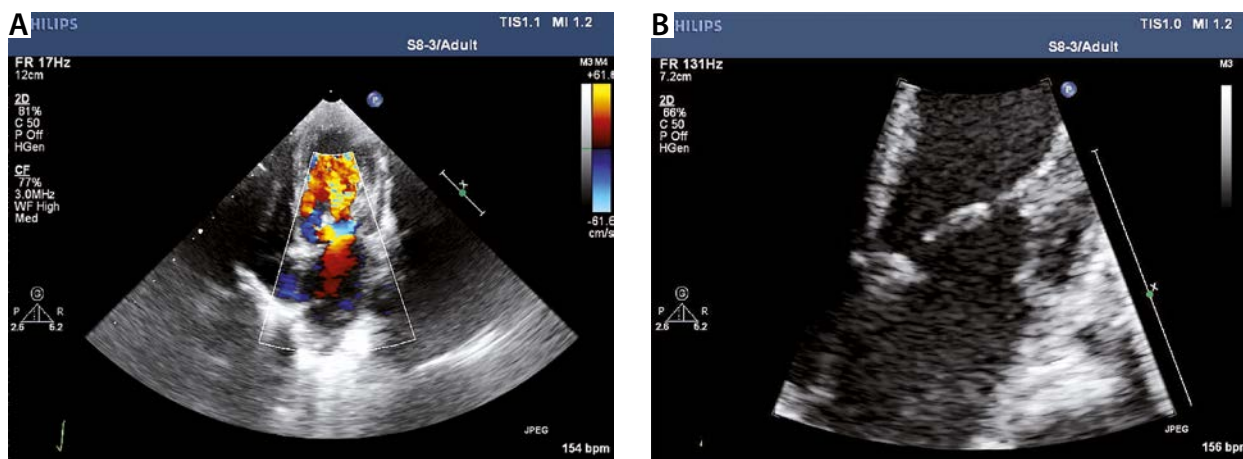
Echocardiographic examination before plasty of the mitral and aortic valve
